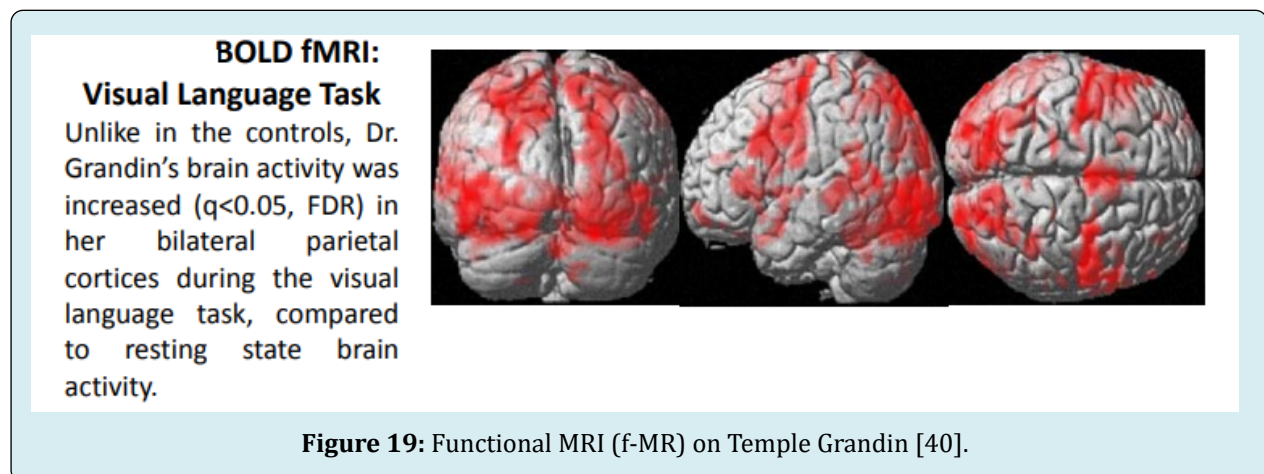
Functional MRI (f-MR) on Temple Grandin [40].
